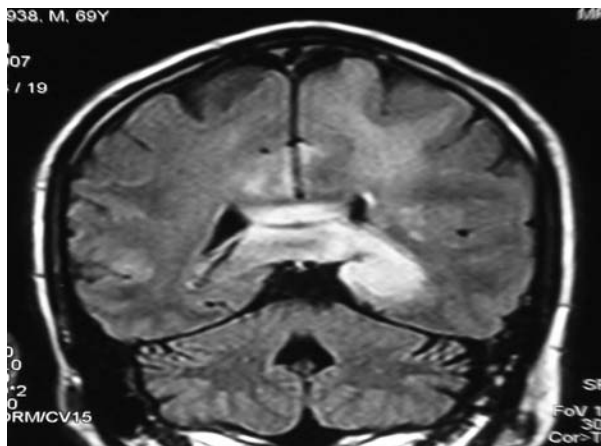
Baseline MRI. Coronal T2 FLAIR image showing hyperintense lesions in the left temporal lobe in the hippocampal region. Also evident are diffuse asymmetrical white and grey matter hyperintensities in the parietal lobe as well as corpus callosum.
